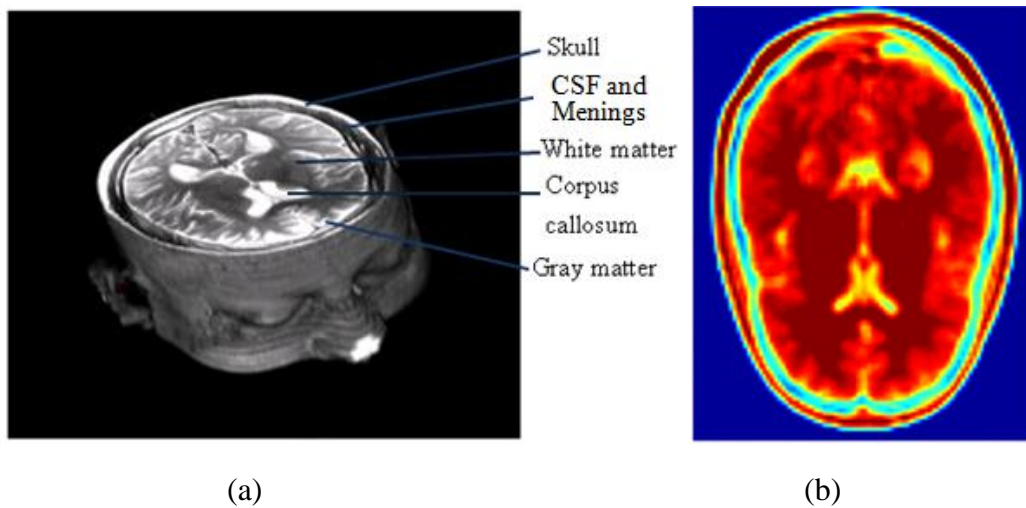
(a) Anatomical structure of human head [58]; (b) Magnetic resonance image
